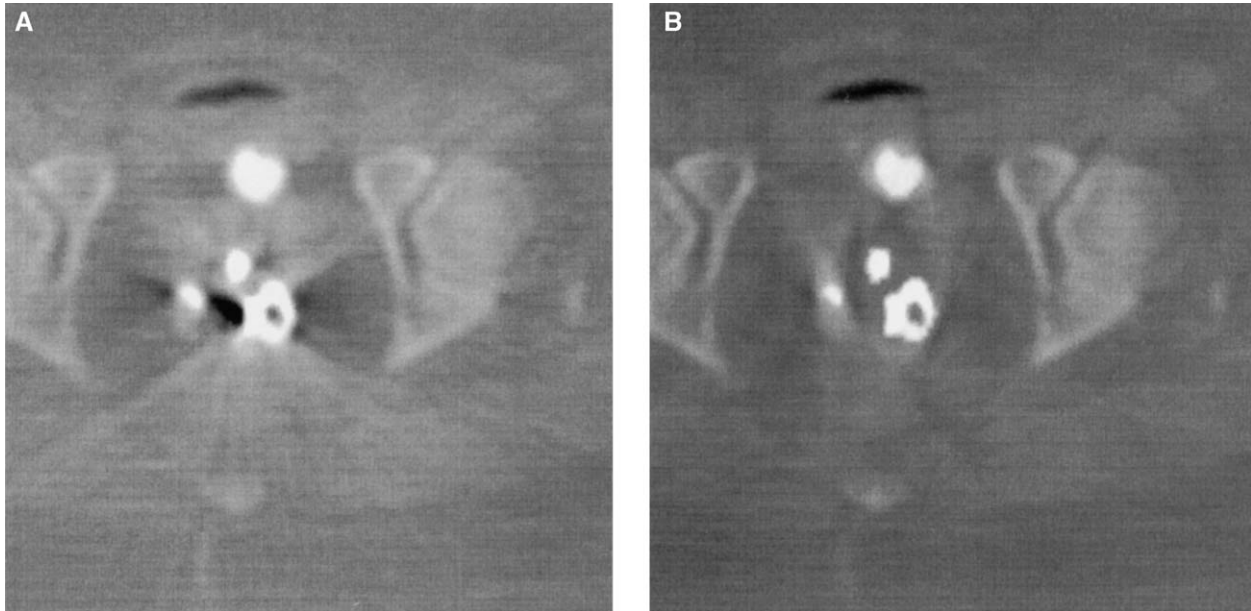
CT scan showing the top of the colpostats, tandem and contrast in the Foley catheter (a) before and (b) after artifact reduction.
